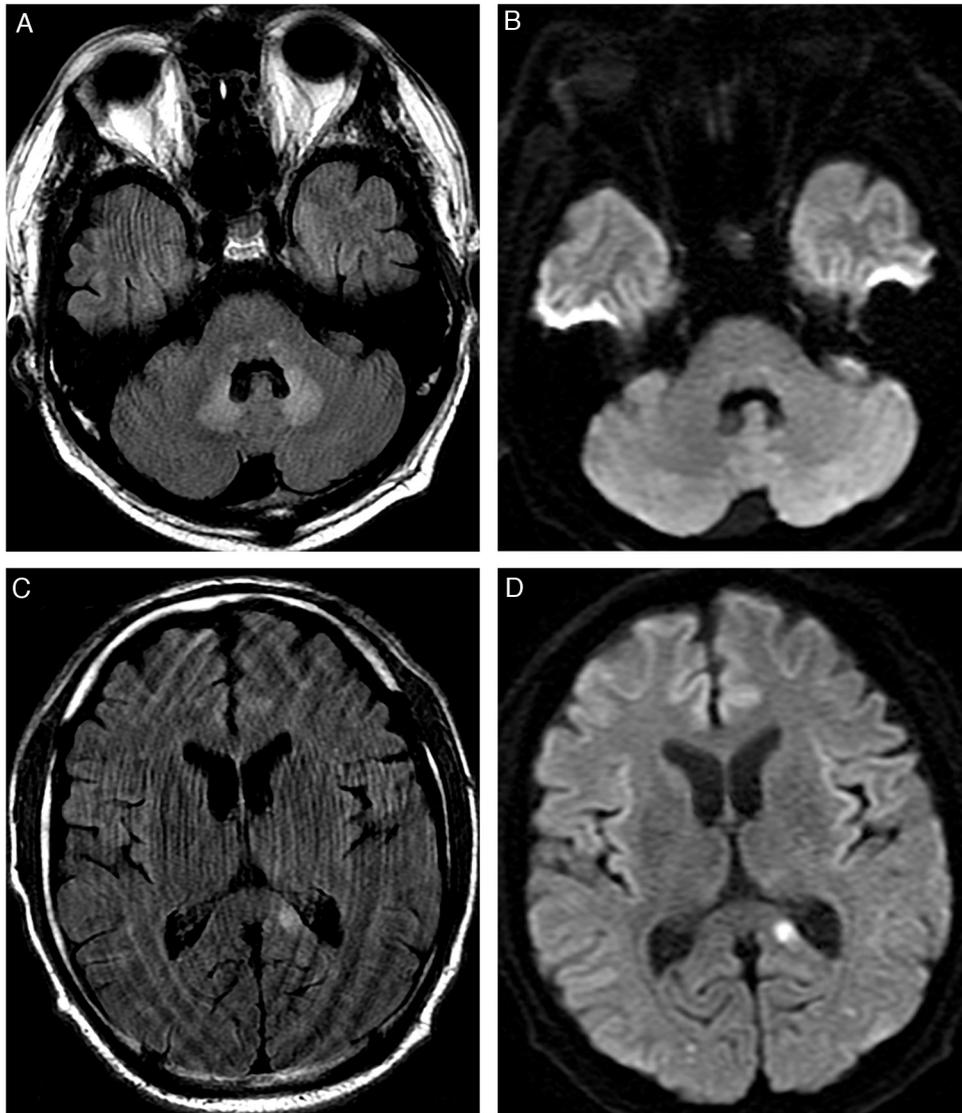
The dentate nuclei demonstrating characteristic hyperintensity on T2-FLAIR (A), without reduced diffusion on DWI (B). There is a cytotoxic lesion of the corpus callosum in the splenium to the left of the midline with T2-FLAIR hyperintensity (C) and diffusion restriction (D) with a low ADC (not shown). (FLAIR, fluid-attenuated inversion recovery; DWI, diffusion-weighted imaging; ADC, apparent diffusion coefficient).
